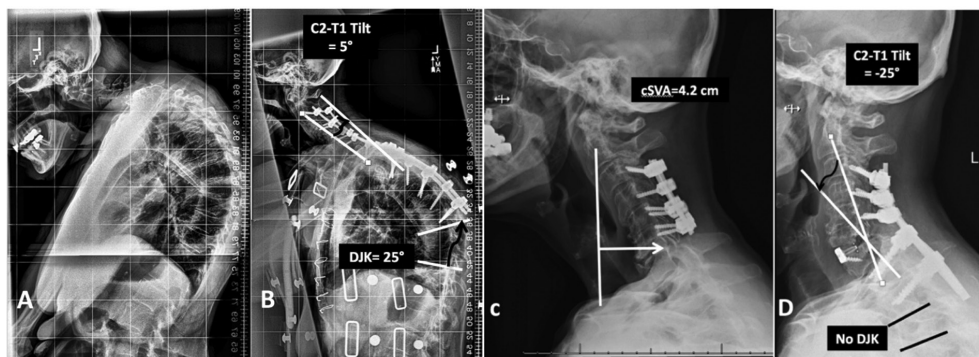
(A) Preoperative X-ray of a cervical deformity patient. (B) Postoperative X-ray of the patient demonstrating the development of Distal Junctional kyphosis (DJK). The in-construct measurement, C2-T1 Tilt (Angle of a line from the centroid of C2 to the centroid of T1 and a line parallel to the posterior vertebral body of T1) quantifies alignment in the fusion construct. (C) Preoperative X-ray of a different cervical deformity patient. (D) Postoperative X-ray demonstrating excellent correction with combined anterior/posterior osteotomies at C6-7. The in-construct measurement, C2-T1 Tilt = -25° and there is no DJK.
